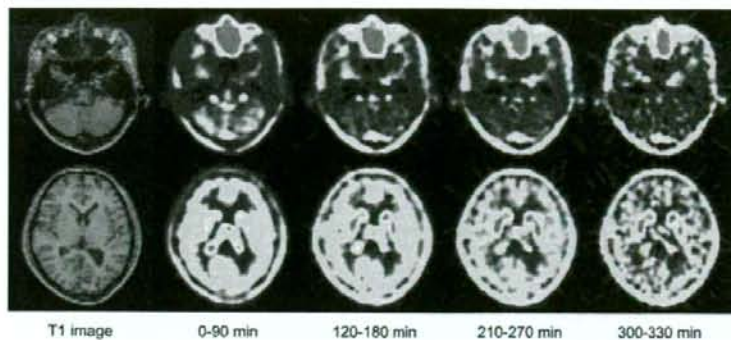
Typical summed PET images of ^{18}F -FE-SPA-RQ and T1-weighted MR images. Upper row shows slice of cerebellum, and lower row shows slice of caudate, putamen, and cerebral cortex.
